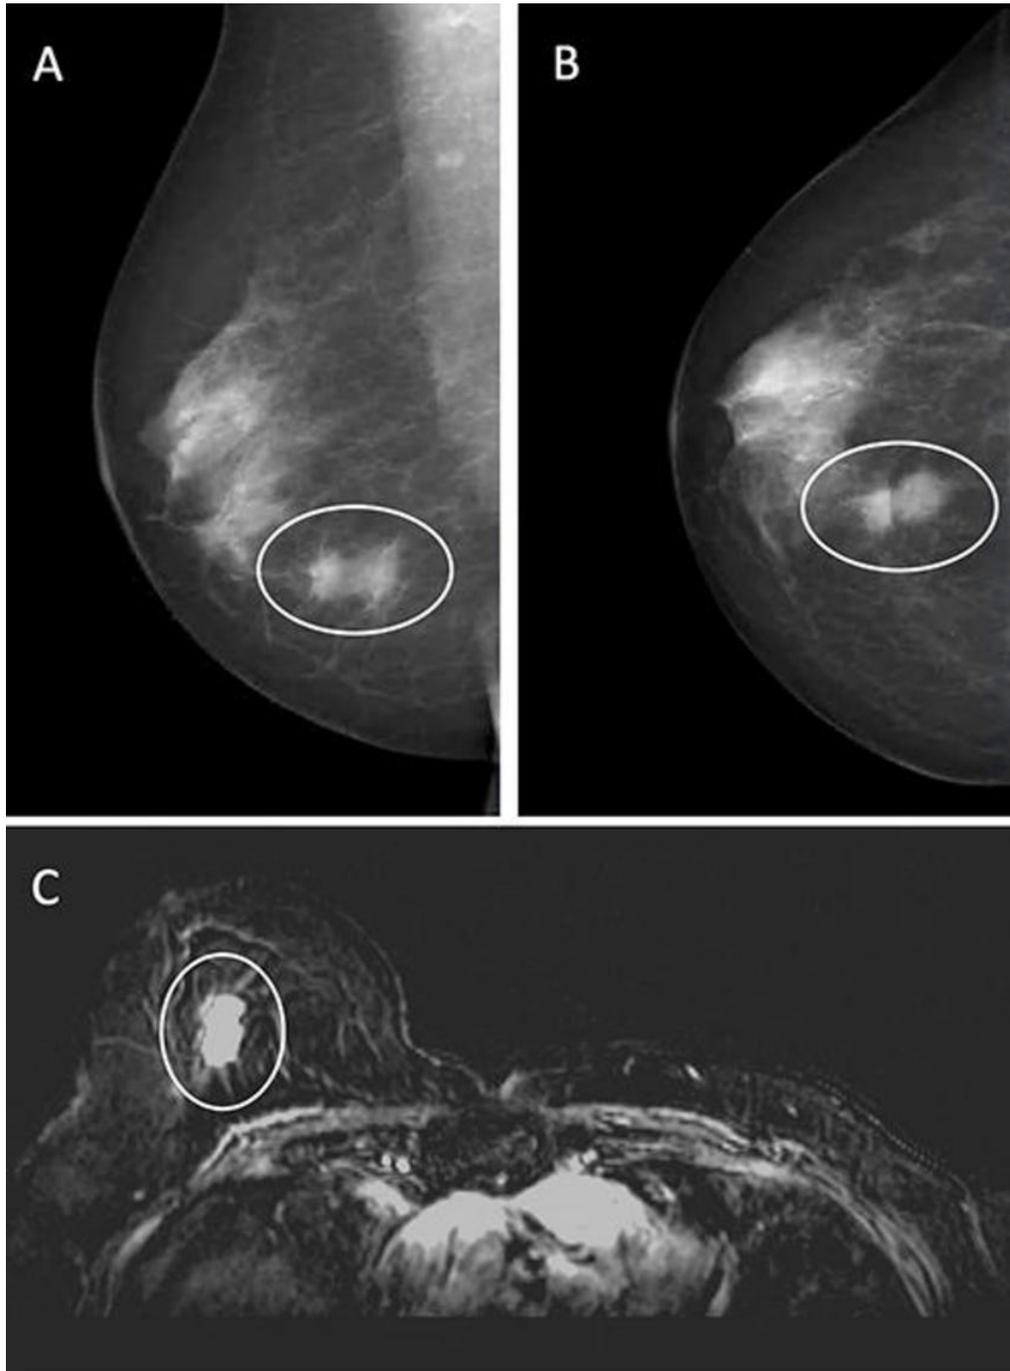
Images in a 67-year-old woman with a prior history of breast cancer who underwent combined mammography and MRI screening. (A) Mediolateral oblique and (B) craniocaudal mammograms and (C) axial subtraction MRI scan show a screen-detected second primary breast cancer (circle) in the right (contralateral) breast. In this case, the MRI was not necessary for cancer detection as the reporting radiologist recalled the woman based on the mammogram. The artificial intelligence system provided a case-based cancer suspicion score of 10 on a scale of 0–10. [High-res. \(TIF\) version](#)
